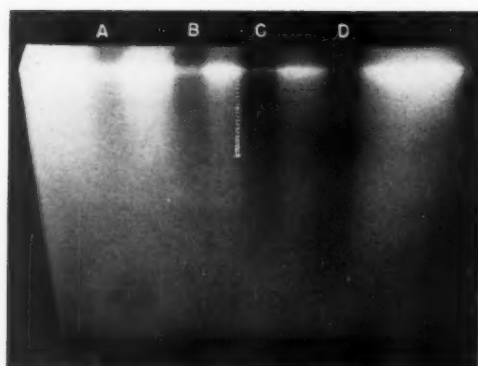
Intensification of color with increased dose of x-rays (280 kvp, 1.3 mm. Cu h.v.l.). A. 500 r. B. 1,000 r. C. 2,000 r. D. 4,000 r.
